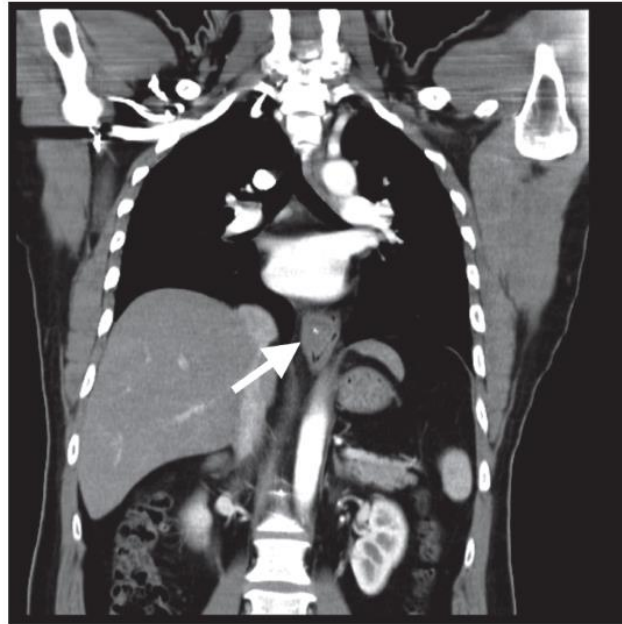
Chest computed tomography revealed a hemangioma in the low esophagus (arrow).
